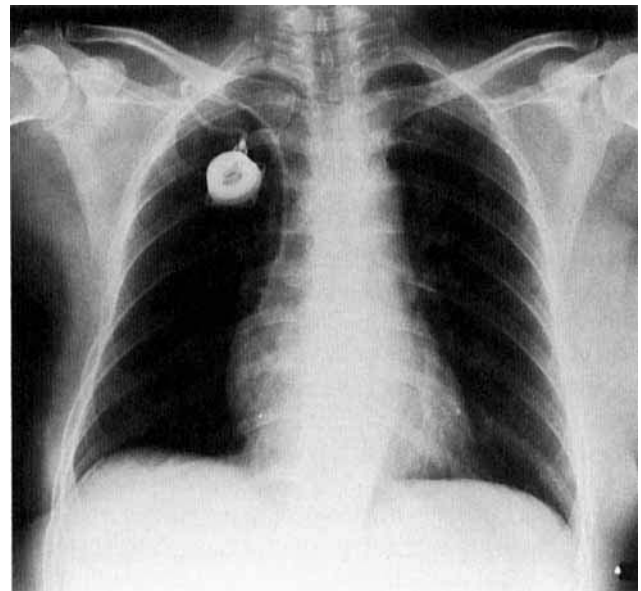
Case report 2. Postoperative chest radiograph, documenting a pinch-off sign grade 2 with considerable angulation of the catheter below the clavicle.
